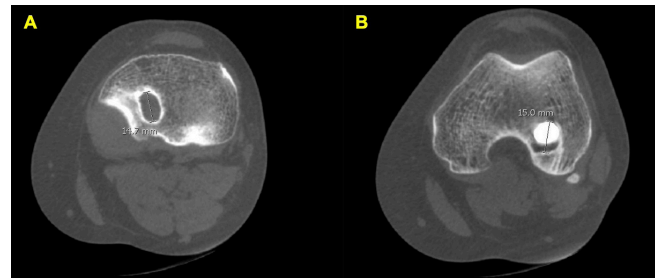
(A) Axial plane computed tomography (CT) scan demonstrating tunnel enlargement (≥ 14 mm) in the tibia, with diameter measurement. (B) Axial plane CT scan demonstrating tunnel enlargement (≥ 14 mm) in the femur, with diameter measurement.
